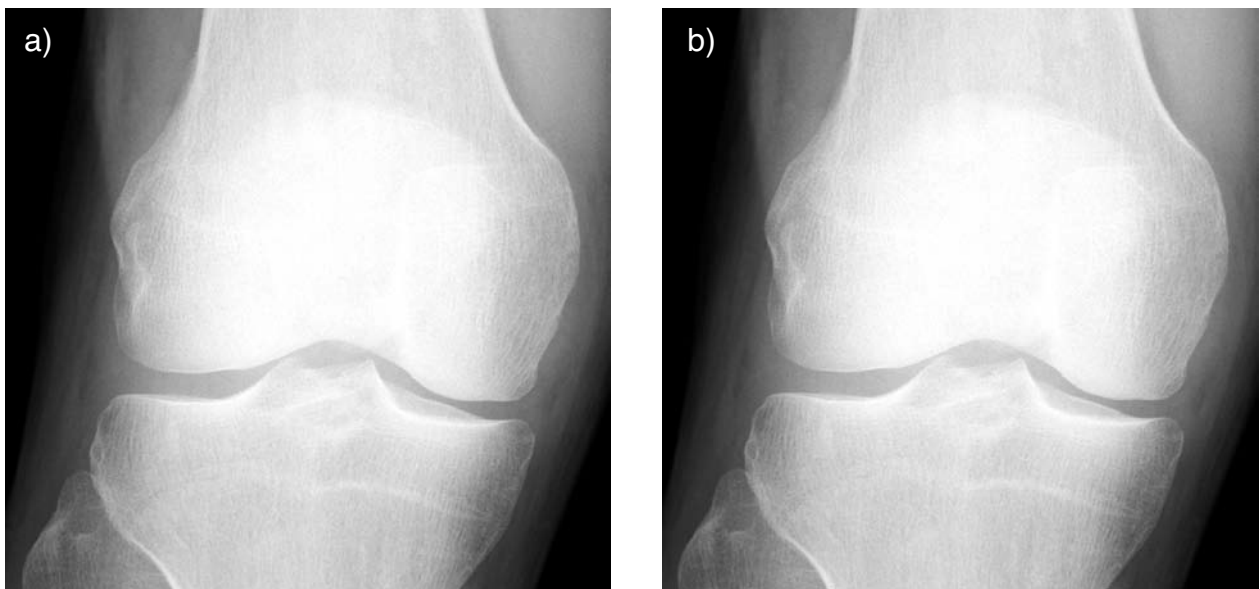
Conventional radiographic examinations in the standard projection of the right knee were normal; frontal (a) and (b) lateral views
